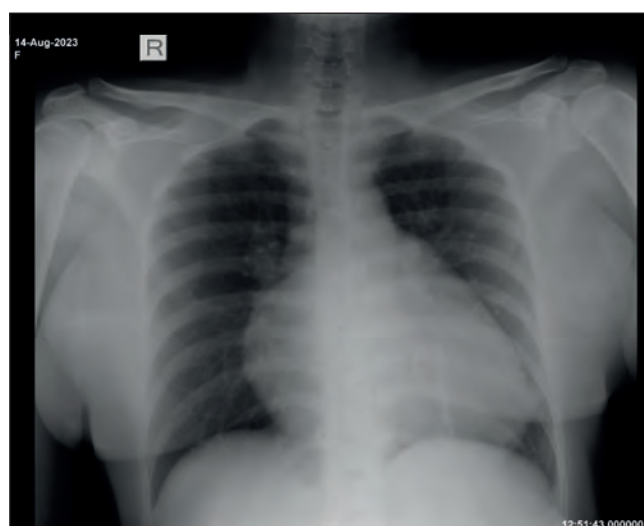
Chest X-ray on initial presentation showing prominent CTR 68%. CTR – cardiothoracic ratio.
